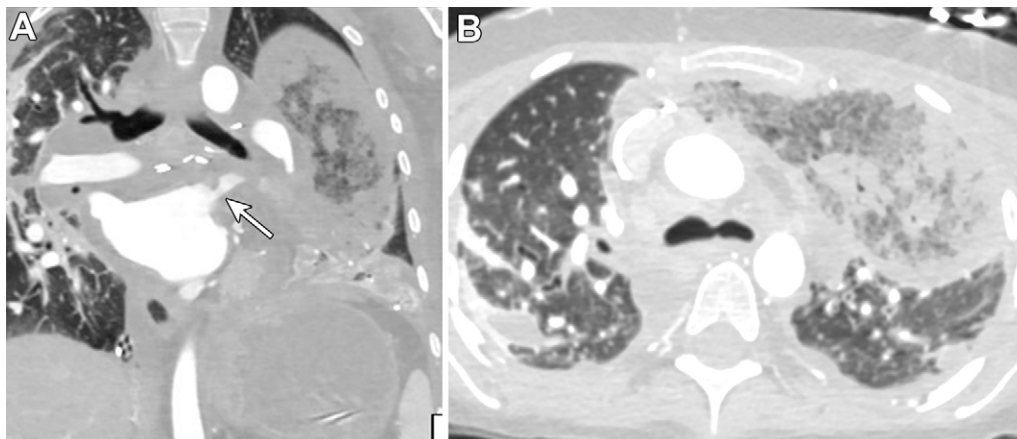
Images in a 49-year-old man with left pulmonary vein stenosis identified 1 week after bilateral lung transplantation for cystic fibrosis. (A) Coronal chest CT bone window image shows stenosis of the left upper lobe pulmonary vein (arrow), and (B) axial chest CT image shows left upper lobe consolidation and ground-glass opacities due to pulmonary venous congestion and likely venous infarction.
